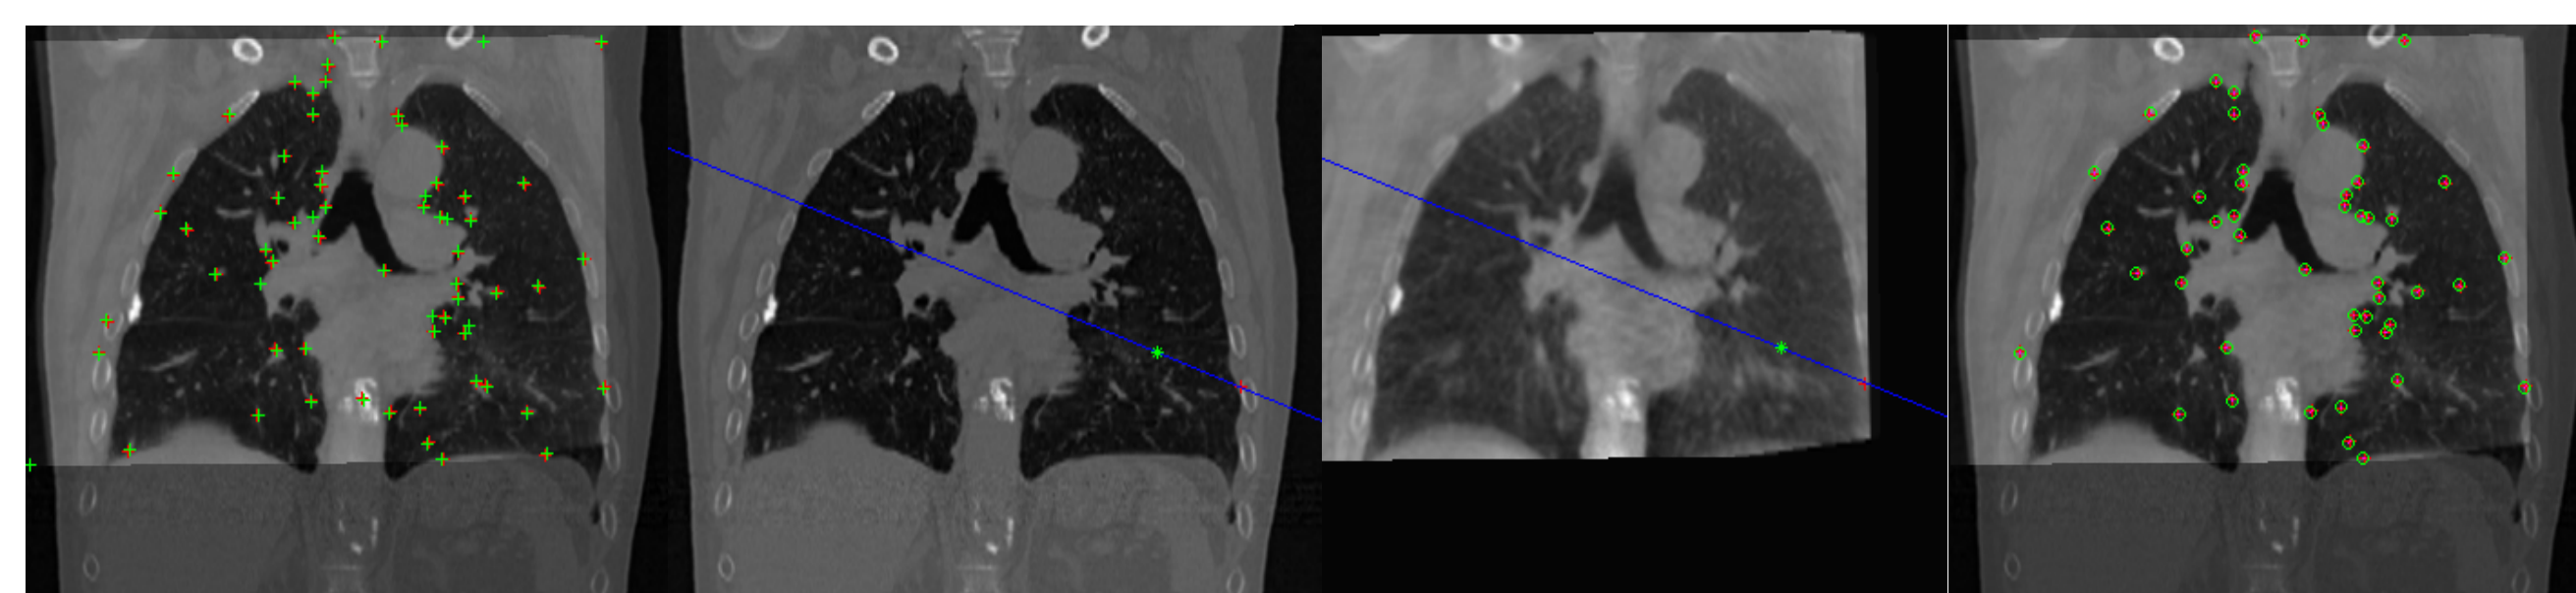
Representative slices containing features used by visual inspection like bifurcation of bronchus, base of the ribs, heart and diaphragm. In first image, a.) the presumptive matches of manual landmarks are represented on overlaid CT and CBCT images. Images b.) c.) shows the RANSAC line fitting for eliminate the outliers. The last image, d.) shows the corresponding landmarks after eliminating the outliers by RANSAC.
